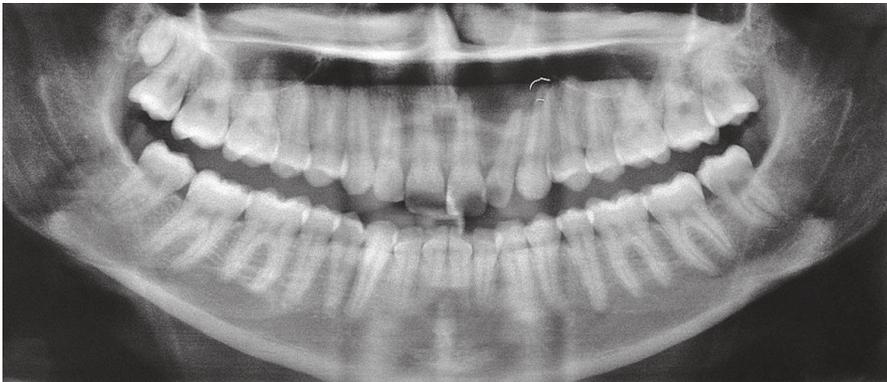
Initial panoramic radiograph. Note the radiolucent area on the apices of teeth #12, 11, 21, 22 and 23, suggestive of necrotic pulp with periapical lesion.
